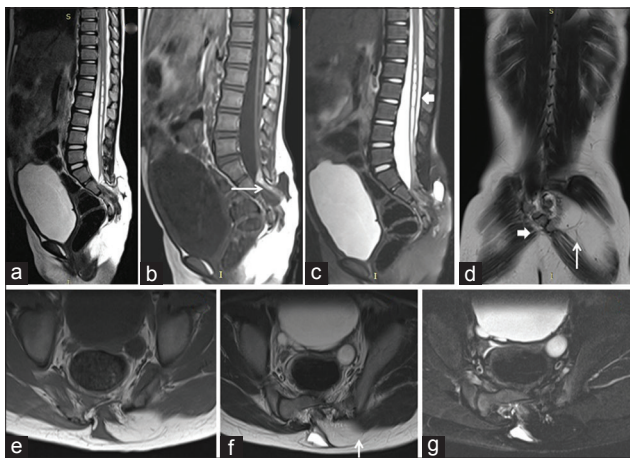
A 4-year-old female child with left buttock swelling, (a) sagittal T2-weighted image, (b) T1-weighted image, and (c) short-tau inversion recovery images show T1 and T2 hyperintense fatty tissue mass in sacral spinal canal (→ arrow) causing tethering of spinal cord with T1 hypo- and T2 hyper-intense syrinx formation (← block arrow). (d) Coronal T2-weighted image, (e) axial T1-weighted image, (f) axial T2-weighted image, (g) axial fat-suppressed T2-weighted images show the extension of fatty tissue via sacral defect into left buttock (↑ arrow). The absence of coccyx and left-sided lower sacral segments is noted beyond S2 vertebra (→ block arrow) representing Type IVb caudal regression syndrome.
